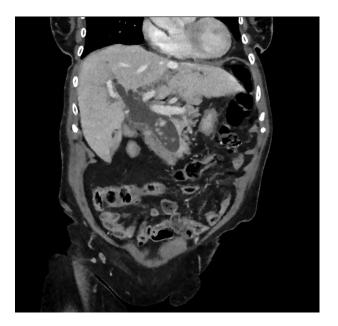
Computed tomography abdomen coronal view reflecting severely dilated common bile duct.
